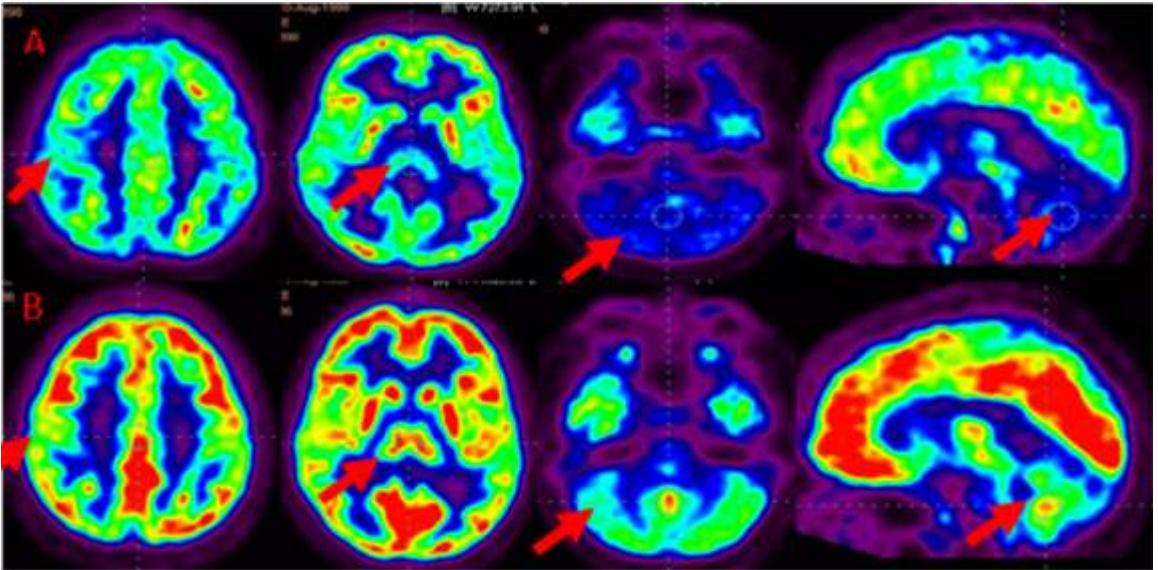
Comparative PET CT scan showing improvements before and after cellular therapy. (A) Pre-PET image before cellular therapy shows reduced metabolism in bilateral sensory motor cortex, parietal cortex, thalamus and cerebellum
